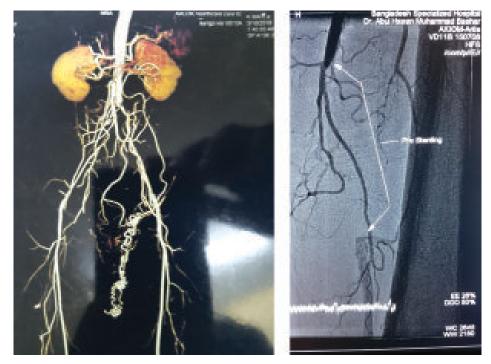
A. Computed Tomographic Angiogram (CTA) showing aorto-iliac occlusion. B. Catheter Angiogram showing occlusion of distal Superficial Femoral Artery.
